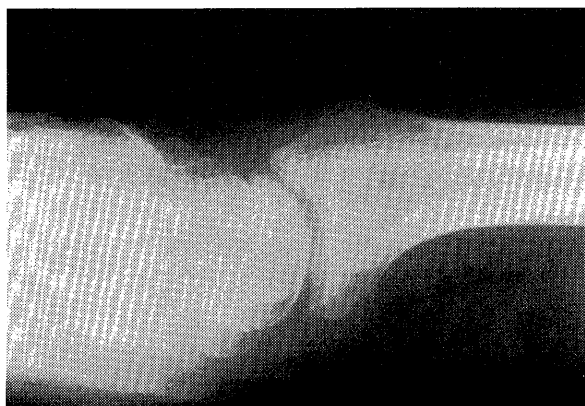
c ; Lateral view of radiograph revealed the improvement of DISI deformity with 20 degrees dorsiflexed lunare.
